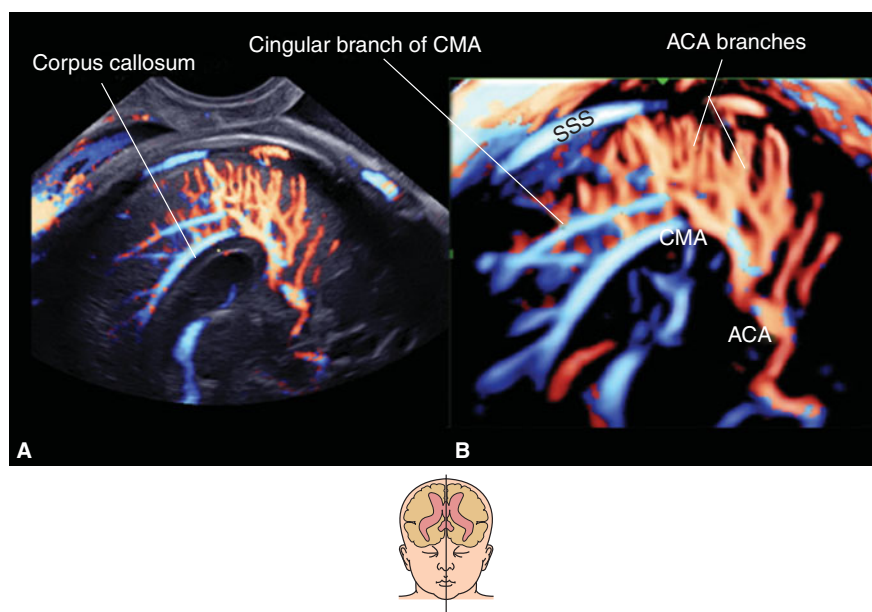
Anterior cerebral artery and its branches in a 24 postmenstrual weeks' normal brain (median view). (A) Two-dimensional (2D) power Doppler image by B-mode demonstrates the corpus callosum (CC). (B) 3D reconstructed angiographic image. ACA, anterior cerebral artery; CMA, callosomarginal artery; SSS, superior sagittal sinus. The cingular branch of the CMA runs along the cingulate gyrus.
